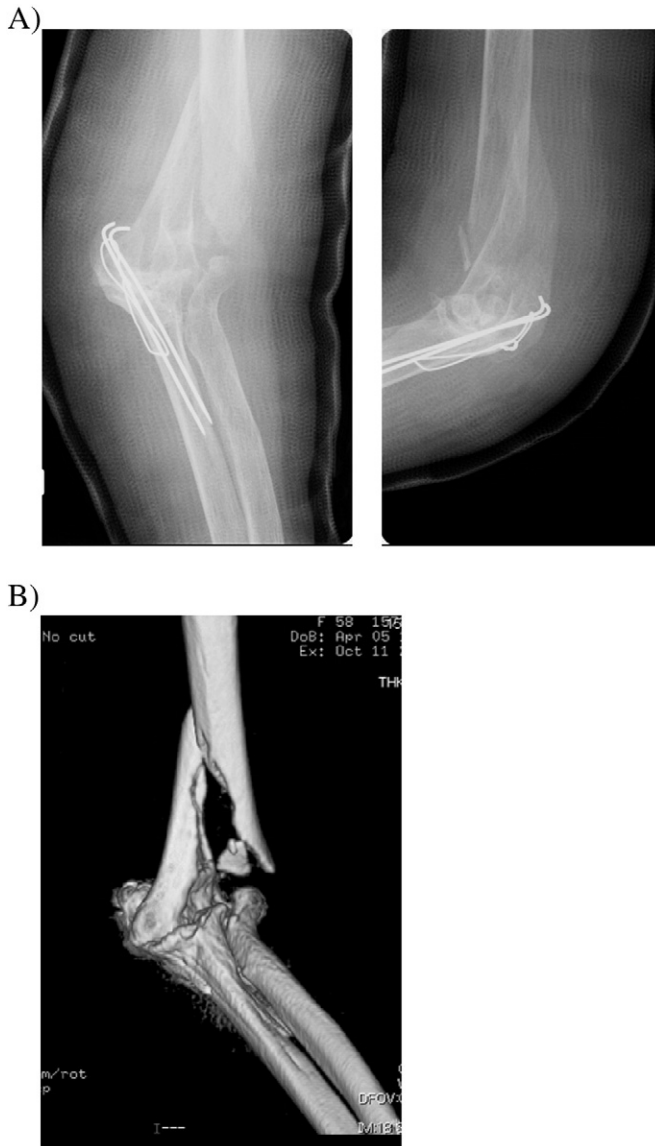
Preoperative X-rays (A) and a 3D-CT image (B) of the left elbow. A comminuted distal humeral fracture of the left elbow was detected.
